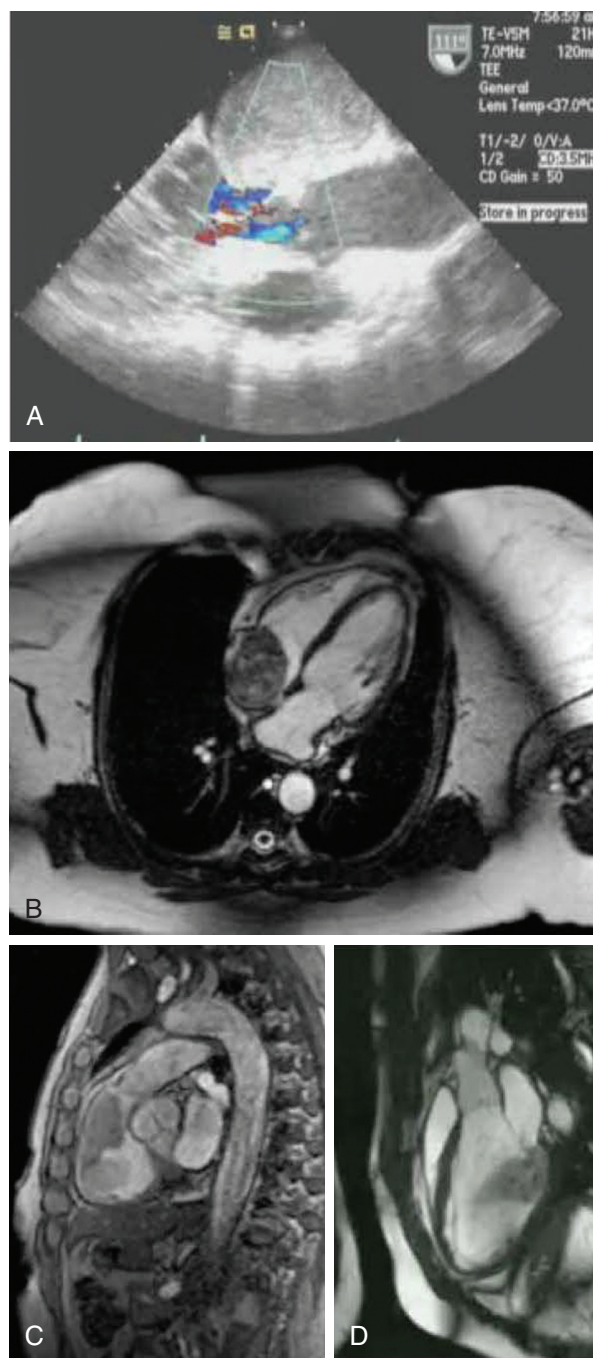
■ Myxomas of the heart. A, Echocardiography of giant left atrial myxoma. B, Magnetic resonance imaging of right atrial myxoma. C, Magnetic resonance imaging of right ventricular myxoma. D, Magnetic resonance imaging of left ventricular myxoma.
